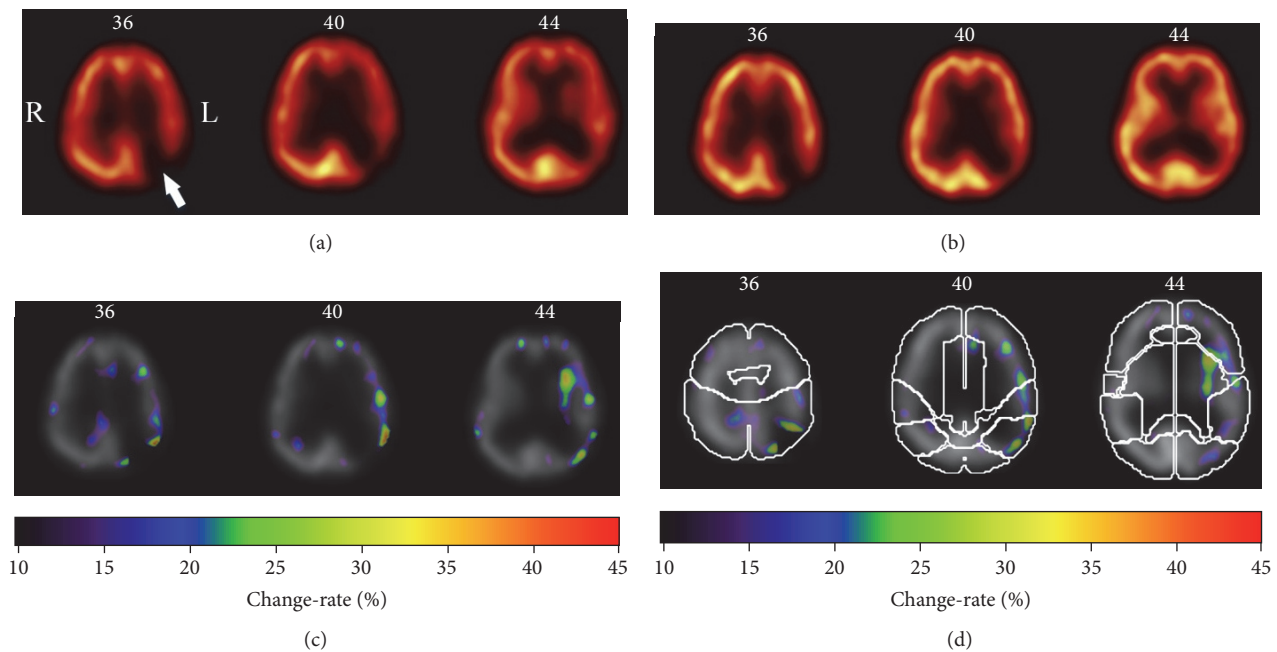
A typical case of treatment monitoring using CAA-CRM approach, where the estimated change-rate map can directly reflect response to treatment. The patient (male, 69-year-old) suffered cerebral infarction in left parietal lobe. While the baseline ^{99m}Tc -ECD SPECT scan was performed 3 days before the treatment of ICA stenting, the follow-up scan was obtained 7 days after the treatment. (a) Three transverse slices (the 36th, 40th, and 44th slices) of baseline SPECT images. The lesion of cerebral infarction is pointed out by white arrow. Around this lesion, the hypoperfusion could be observed. (b) Three corresponding transverse slices of the follow-up SPECT image. There is no improvement in the lesion of cerebral infarction, while the severe recovery is observed for the cerebral ischemia in hypoperfusion regions around the lesion. The recovery level was scaled as severe by the traditional visual inspection in clinical report. (c) Three transverse slices of the derived change-rate map (CRM) fused with baseline SPECT image. The scales of change-rate are presented by rainbow color bar. The warmer color denotes higher change-rate. In this case, the recovered regions can be detected easily and clearly in the change-rate map. (d) The selected transverse slices of the CRM fused with the atlas of brain lobes. The contours of the brain lobes are delineated. The recovered regions can be conveniently localized in the brain area.
